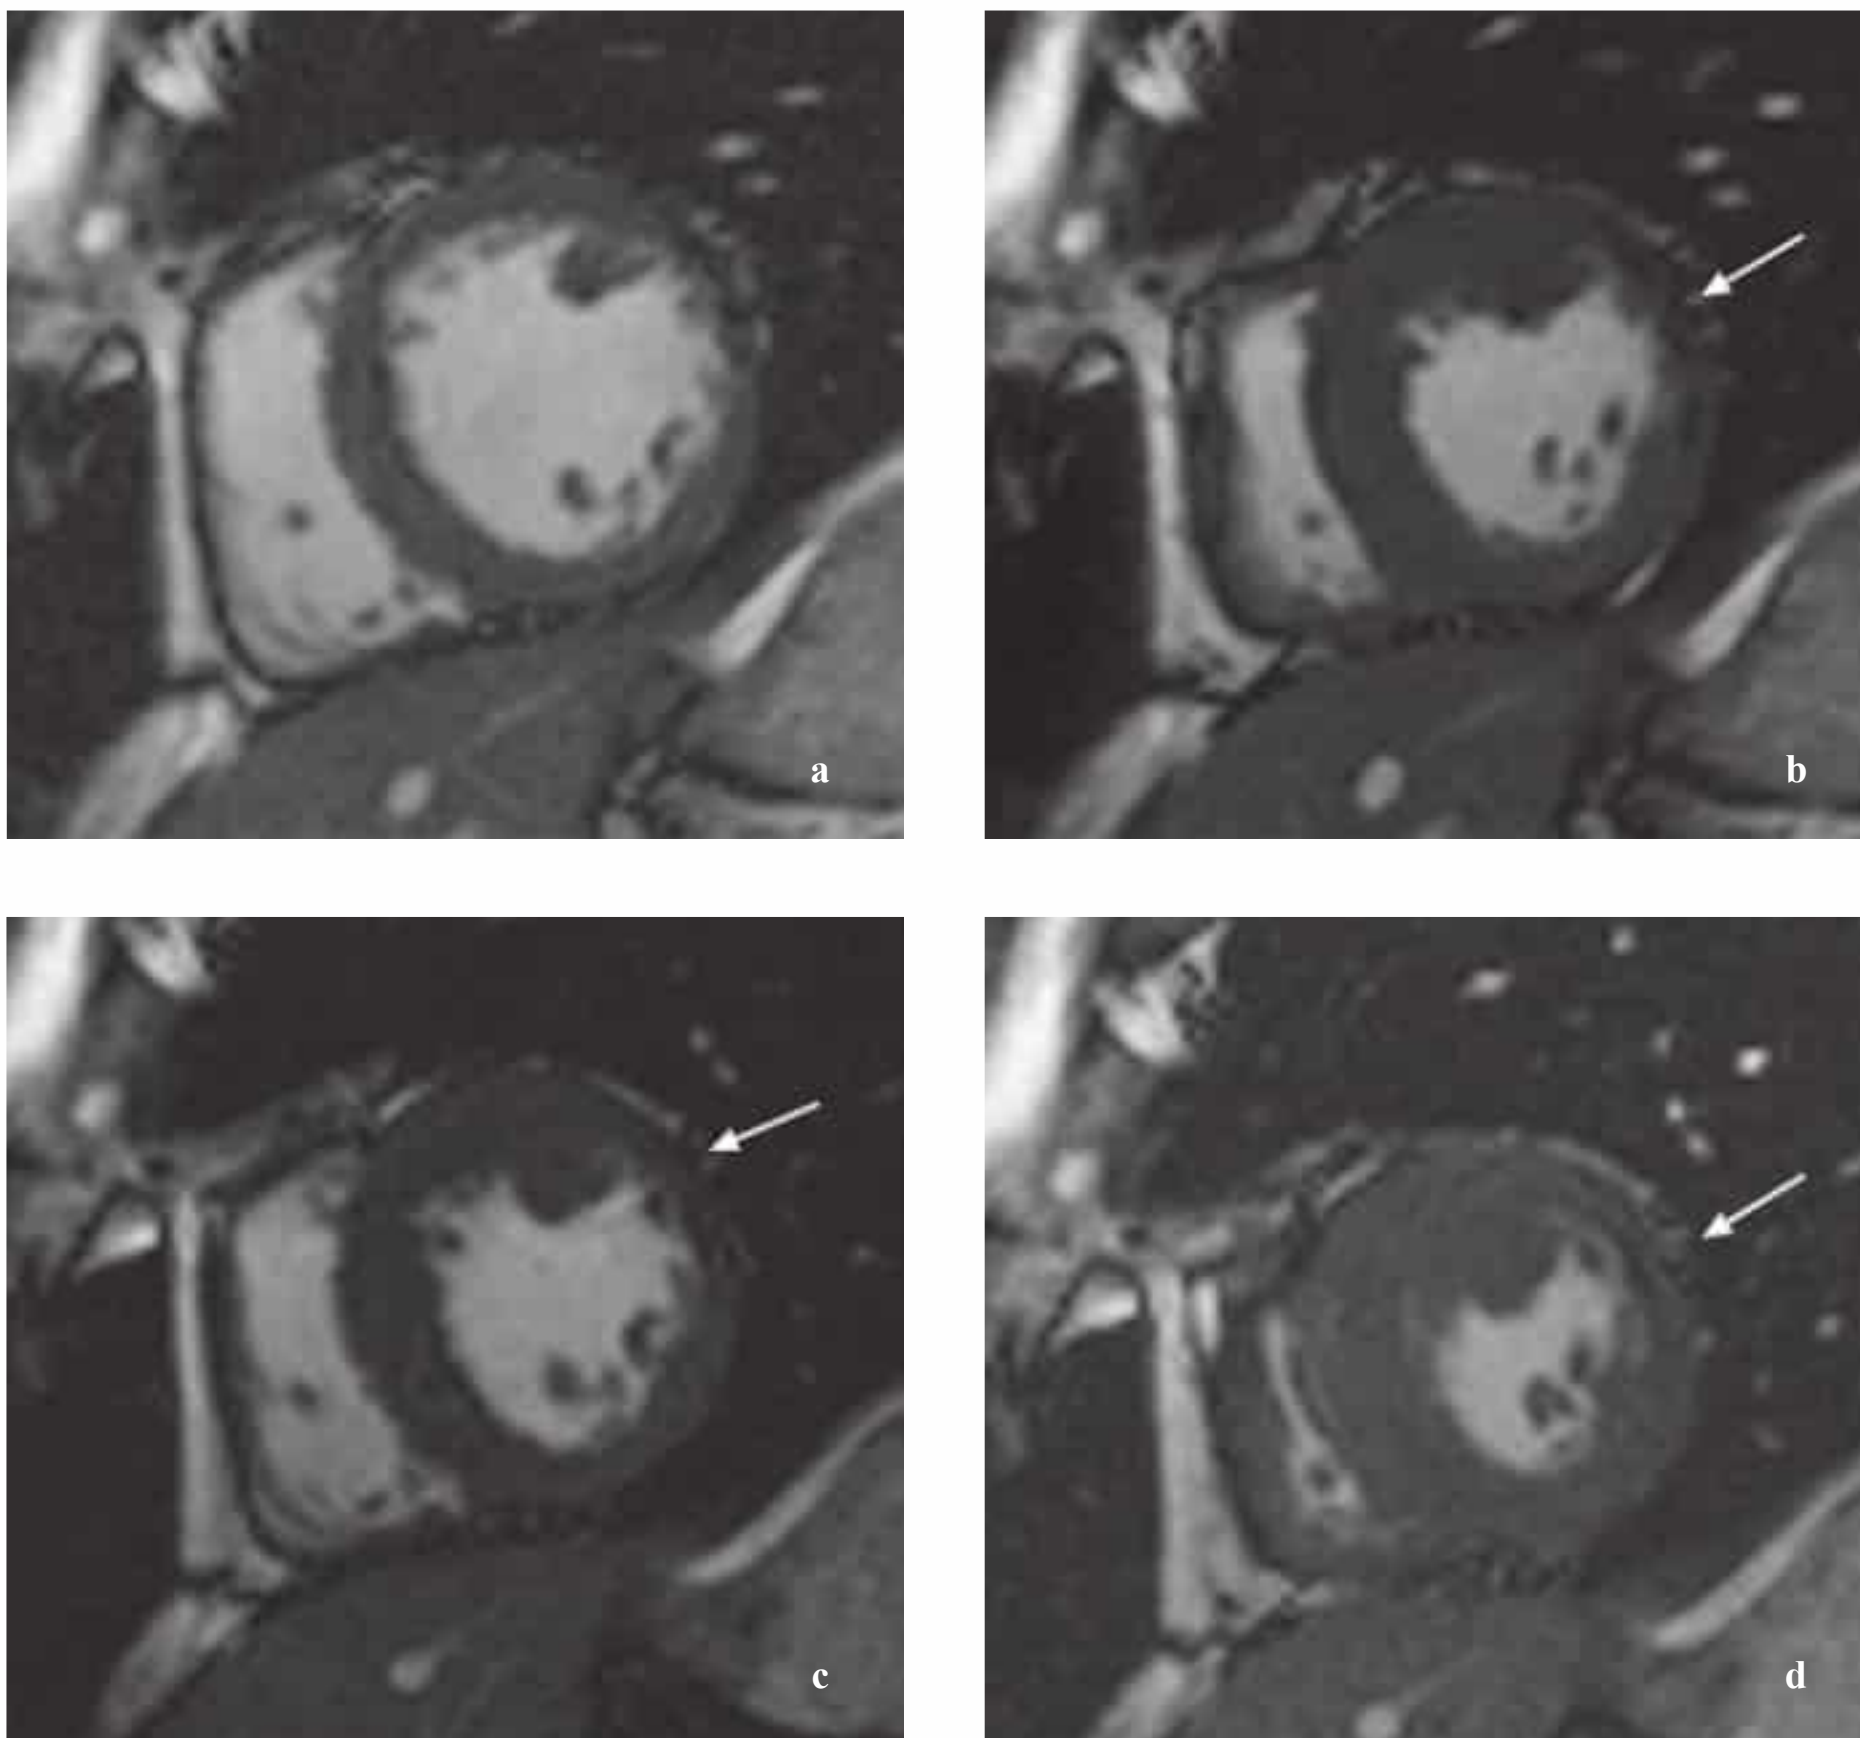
a–d Low-dose dobutamine stress MRI of a transmural myocardial scar. End-diastolic (a) and end-systolic (b) images from a cine sequence at rest and with low-dose dobutamine stress ($10 \mu\text{g}/\text{min}/\text{kg}$ bw) (c, d). The anterolateral segment (segment 12) shows akinesia and wall thinning at rest and during stress due to a transmural scar (arrows). The remaining, viable segments show normal wall thickening in response to stress.
